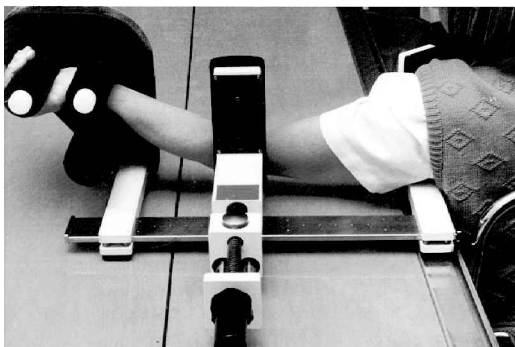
The valgus load device used for dynamic radiography.
